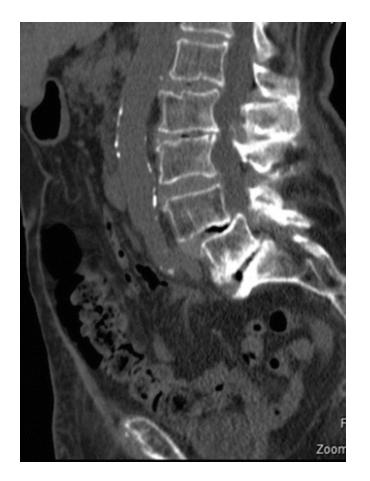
Abdominal CT for acute abdominal pain, but not back pain, in an elderly woman revealed degenerative changes in the lumbar spine, including severe disc degeneration with vacuum phenomenon in several discs and spondylolisthesis with L4 slipped anteriorly on L5
